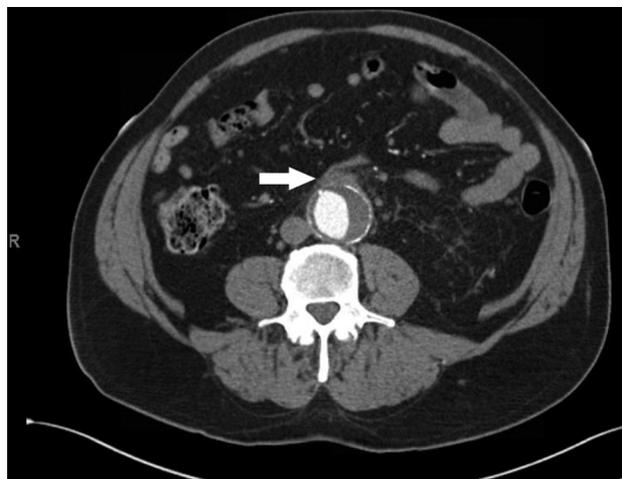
Figure Abdominal CT scan demonstrates fat stranding at the origin of the inferior mesenteric artery (arrow).
